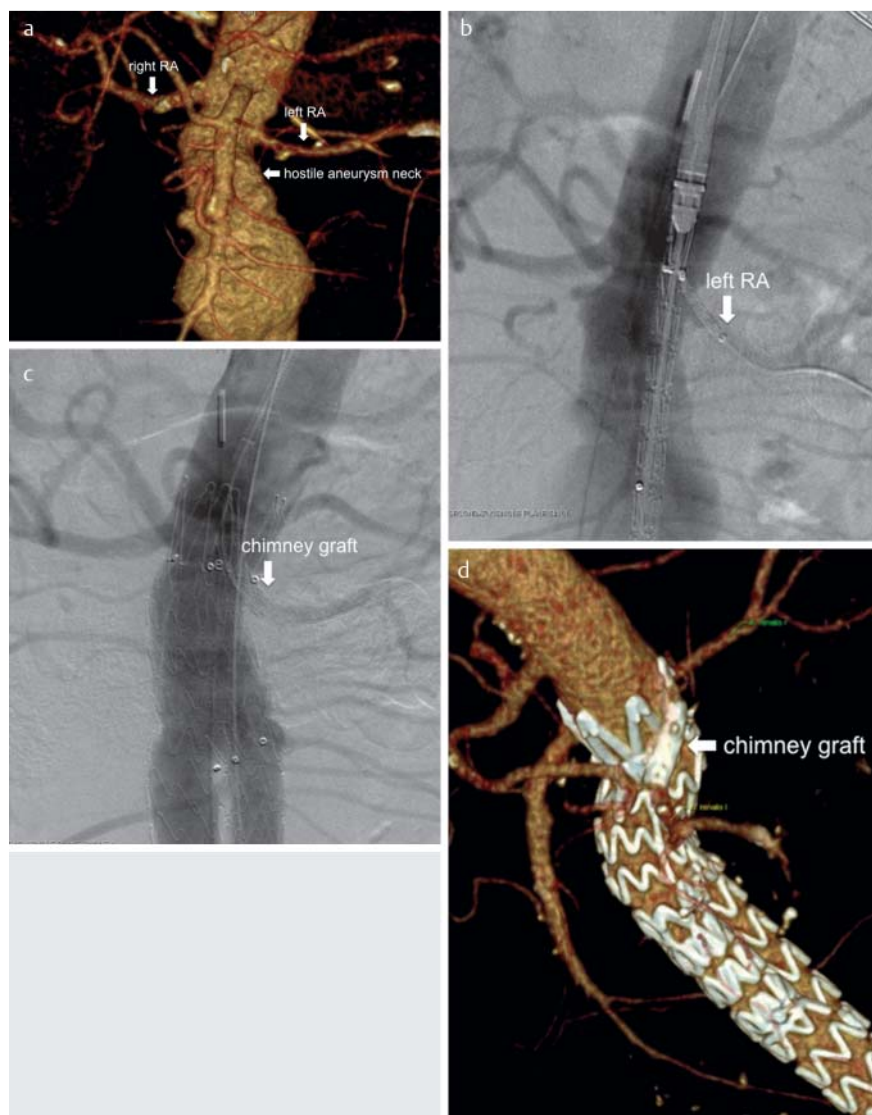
a–d Chimney grafts. 71-year-old male patient with abdominal aortic aneurysm (AAA) with maximum diameter of 52 mm. The pre-interventional CT angiography (CTA) in volume rendering technique (VRT) shows a cone-shaped, short aneurysm neck a. To achieve sufficient graft fixation, the left renal artery has to be covered by the aortic stent graft. The pre-interventional angiogram b shows the aortic stent graft and the covered stent / chimney (Advanta V12 5/22 mm, Atrium Europe, SL Mijdrecht, The Netherlands) placed in the left renal artery via a left brachial access. After deployment of the aortic stent graft and the chimney graft, both stent grafts were dilated simultaneously with balloon catheters (not shown). The final angiogram c shows good perfusion of both renal arteries without any type I endoleak. The VRT of the post-interventional CTA shows the chimney graft running parallel to the aortic stent graft to preserve flow into the renal artery d.
